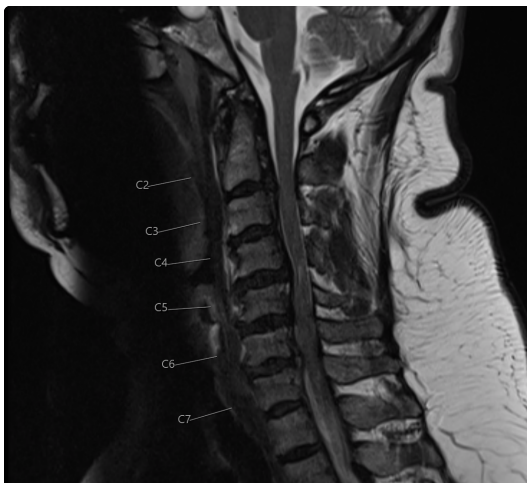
· SAGITTAL T2 CERVICAL MRI
